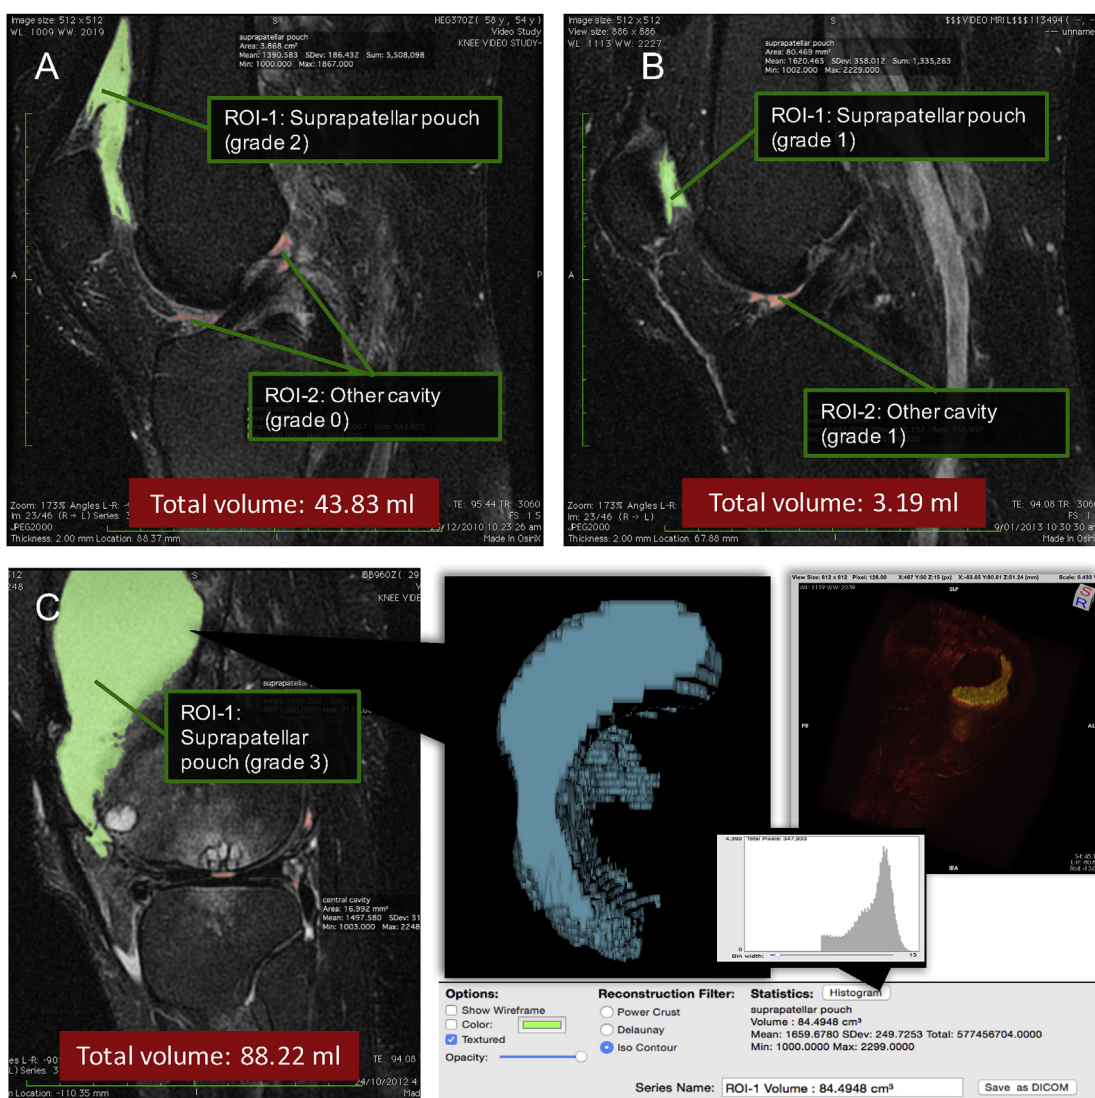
MRI acquired from the knee, with superimposed colour data showing the area of high signal. The images were obtained before (A) and 24 months after (B) intervention. Data were analysed in two ROIs, which were located in the suprapatellar pouch (ROI-1, pixels shown in green) and the other joint cavity (ROI-2, pixels shown in red), respectively. The total volume was generated from the area of each ROI in the entire series of images using OsiriX software (C). Semi-quantitative grades for each ROI were also provided accordingly.
